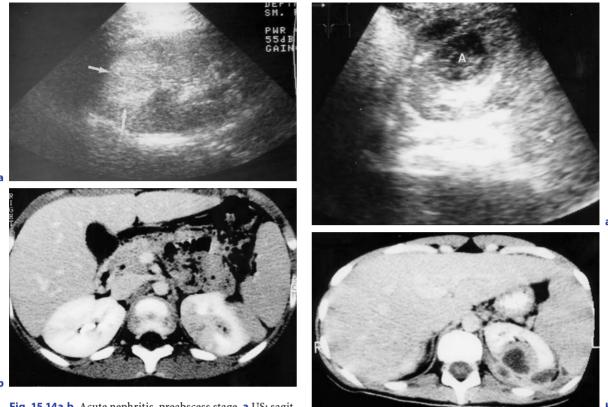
Acute nephritis, preabscess stage. a US: sagittal scan of the left kidney. There is an hyperechoic area at the upper pole (*arrows*). b Corresponding CT after contrast enhancement displays an area of decreased vascularization
